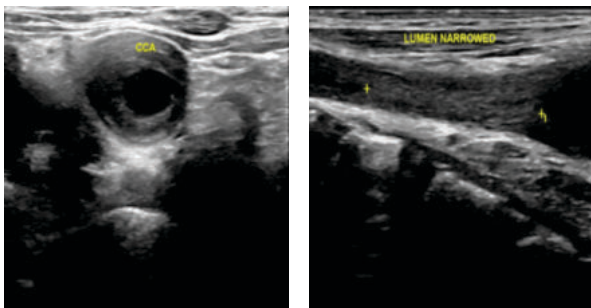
CASE 1: Luminal narrowing of common carotid artery demonstrated in both axial and longitudinal sonographic views.
